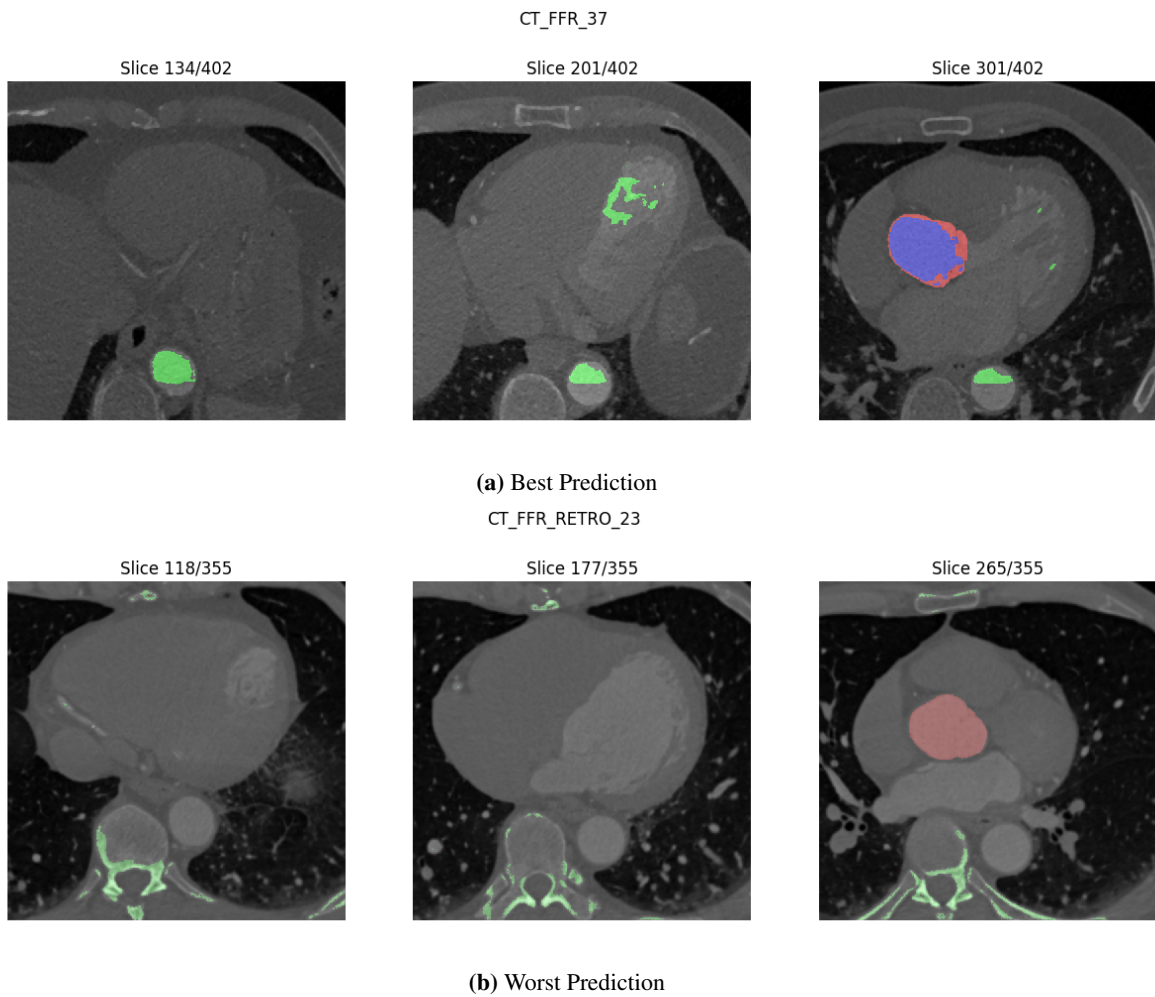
A selection of some of the CT slices of the SegCaps model's best and worst prediction of the Aorta splits, where the corresponding prediction is overlaid. The prediction is color-coded with blue=TP, green=FP, and red=FN
